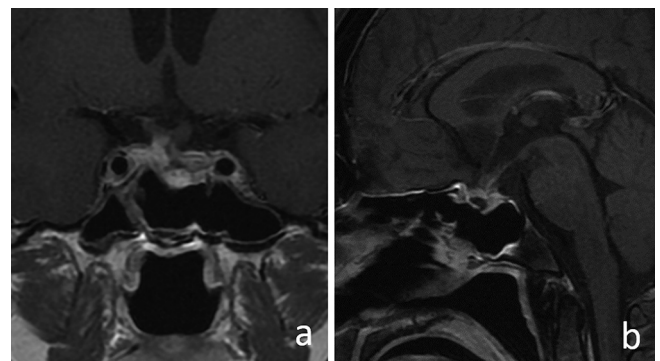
Postoperative MRI after completing the stereotactic radiosurgery showing sufficient mass resection with adequate tumor control (a and b).
